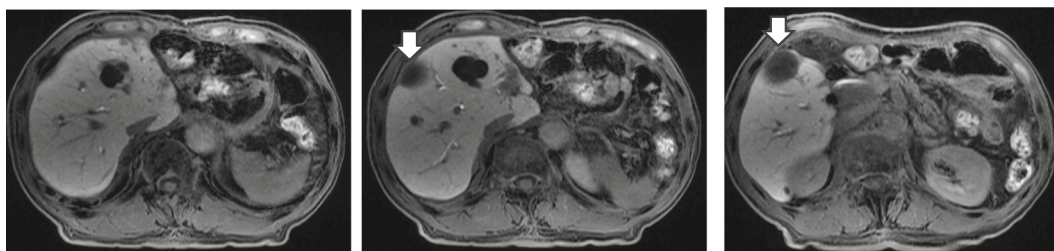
MRI findings. MRI after hepatectomy showing no recurrence and fluid collection on the dissected surface of the liver in the hepatocellular phase (white arrow).
